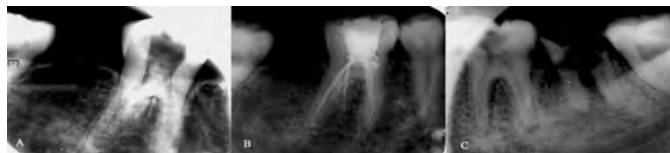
(Left) Preoperative diagnostic radiograph showing the presence of a radix entomolaris on the mandibular left first molar. (Center) Post-obturation radiograph confirming the presence of a radix entomolaris on the mandibular left first molar. (Right) Radiograph of the mandibular right first molar showing no extra root. Case is a 27 year old female.
